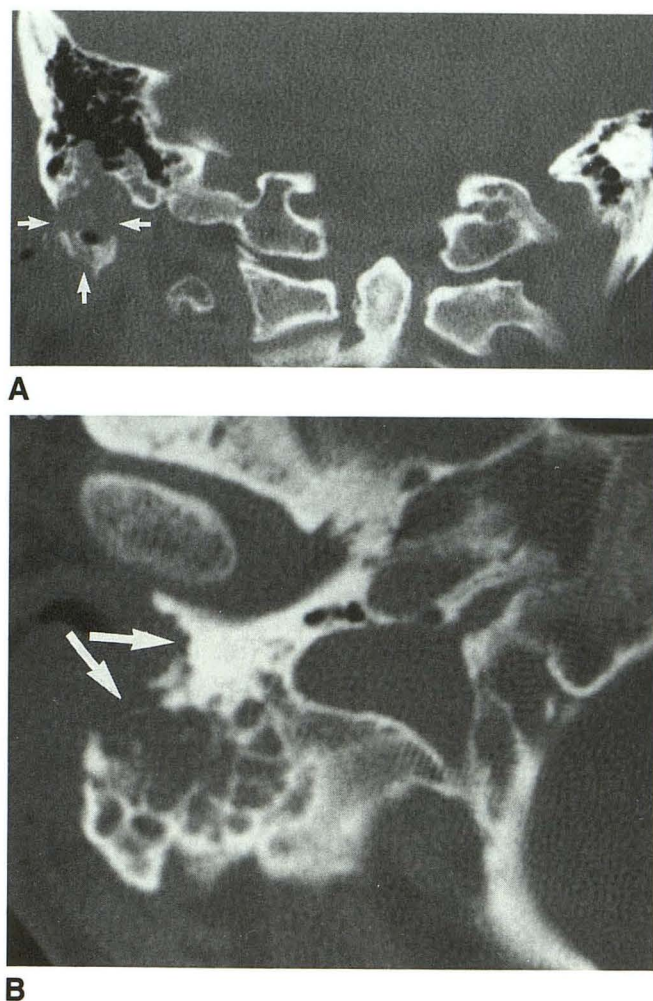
Recurrent basal cell carcinoma of right ear. A and B, CT shows bone erosion of inferior mastoid and styloid process (arrows).
